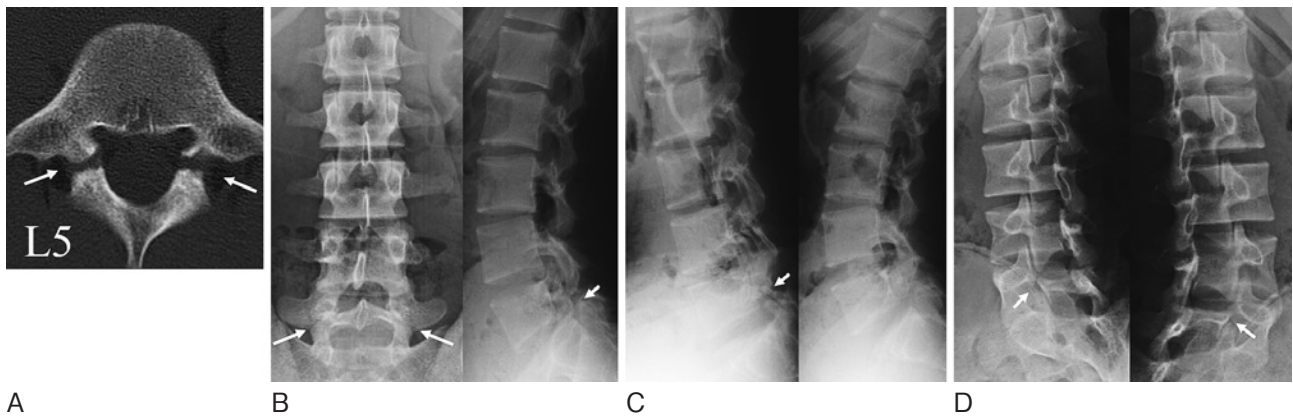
A reconstructed CT scan and plain radiographs of a 15-year-old boy with terminal spondylolysis. (A) An oblique-axial CT scan shows pseudoarthrotic changes in the pars interarticularis (arrow). (B-D) Plain radiographs including anteroposterior, lateral (B), dynamic lateral views (C) and oblique views (D), on which fracture lines are clearly identified (arrow heads).
